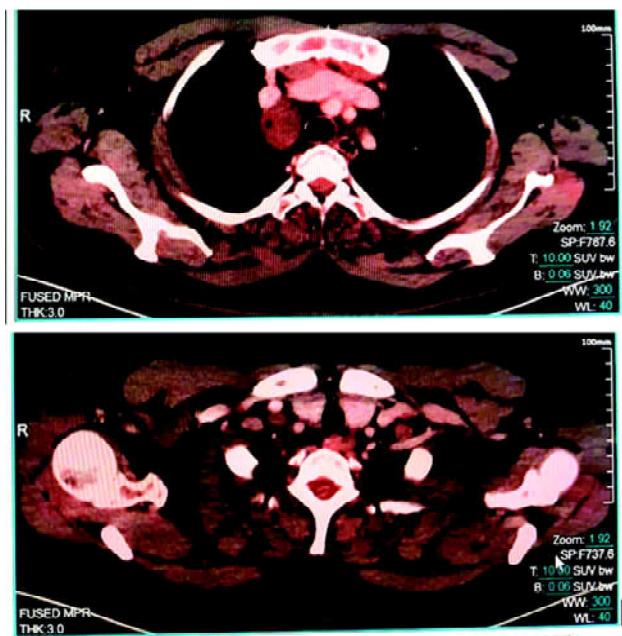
PET-CT images showing resolution of hypermetabolic bone lesions.
